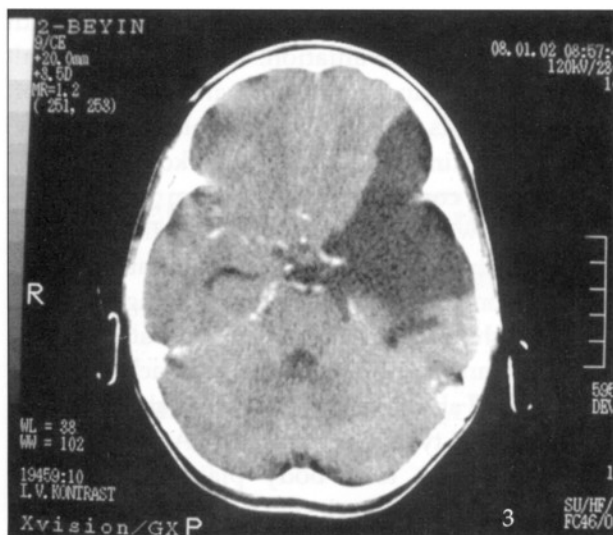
Computed tomography axial views, 3) large hypodense area at the left temporoparietal region without apparent mass-effect and enhancement, 4) a right parietal bone defect
